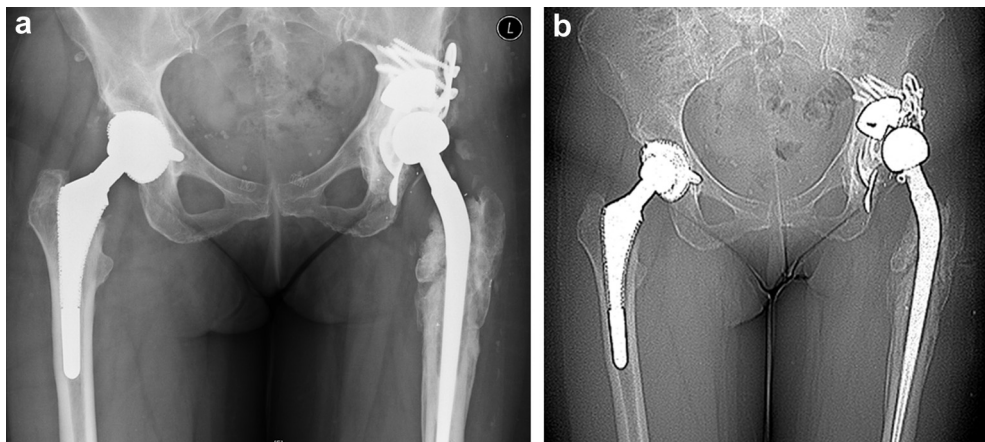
Premature implant failure of the antiprotrusion cage in anteroposterior radiograph (a) and computed tomography scan (b).
